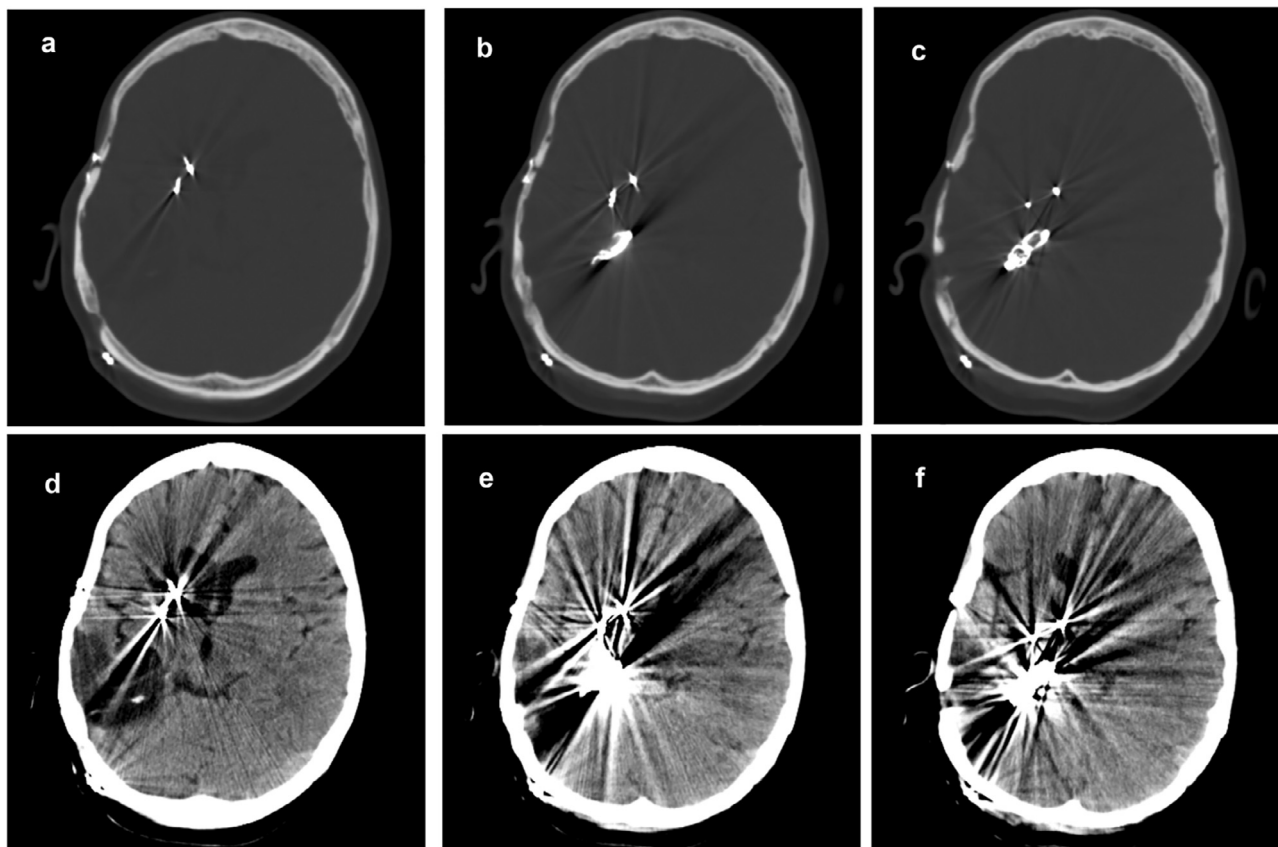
Right Posterior Cerebral Artery Stroke Axial head CT without contrast obtained 6 years after neurosurgical clipping of right posterior cerebral artery (PCA) showing diffuse hypodensity and encephalomalacia in the right PCA vascular territory.
